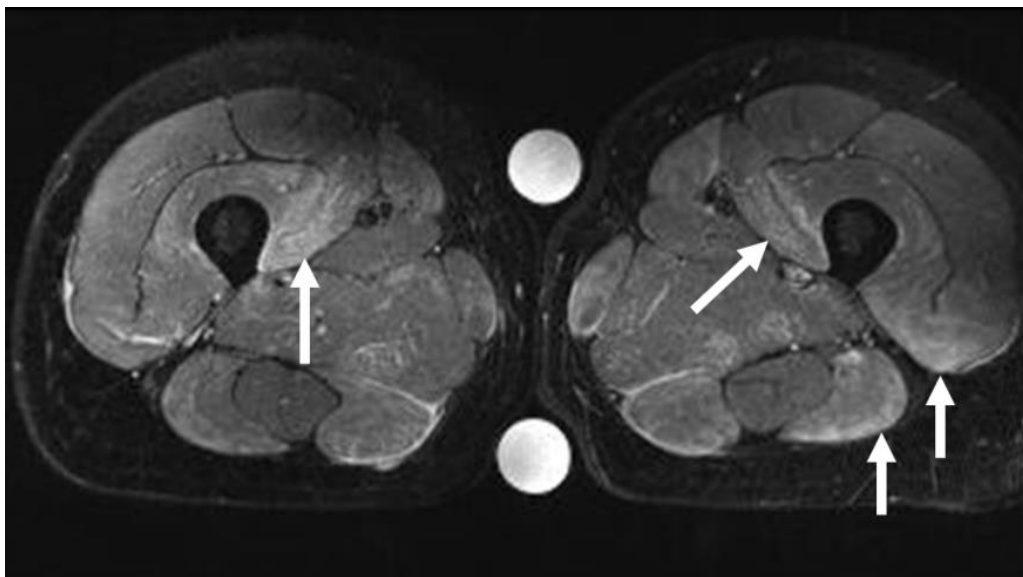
T2-weighted image of the thighs with application fat-saturation (STIR). Inflammation sites are indicated by arrows. Note the hypo-signal from subcutaneous fat and bone marrow because of the application of fat saturation.
